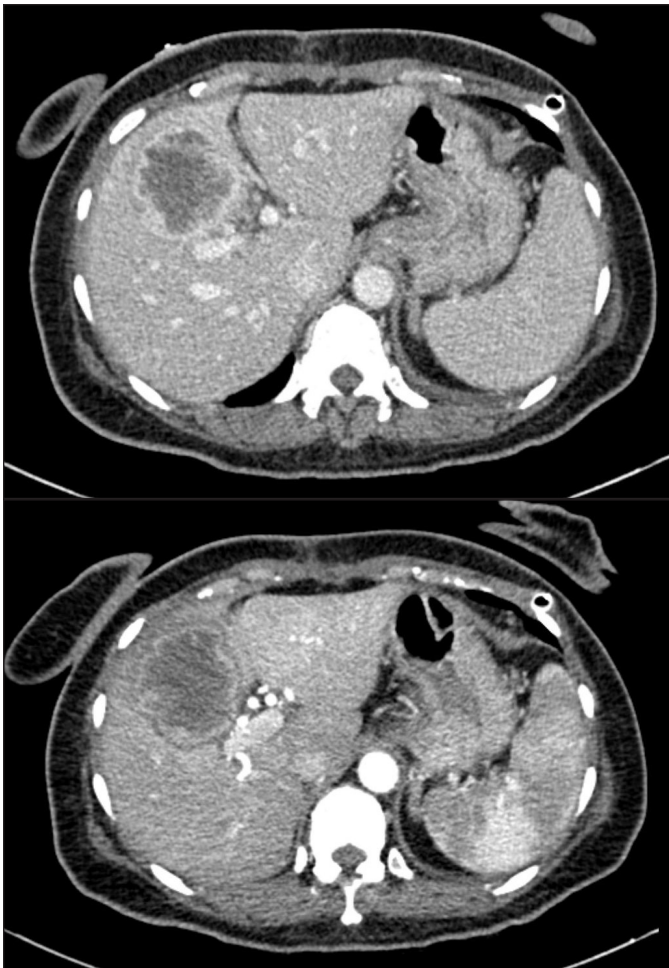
Sequential axial images in the arterial, portovenous, and delayed phases of triple-phase CT contrast enhancement demonstrating gradual centripetal enhancement. Specifically, the central areas of the mass are retaining the contrast, consistent with the fibrous nature of the ICC matrix.
